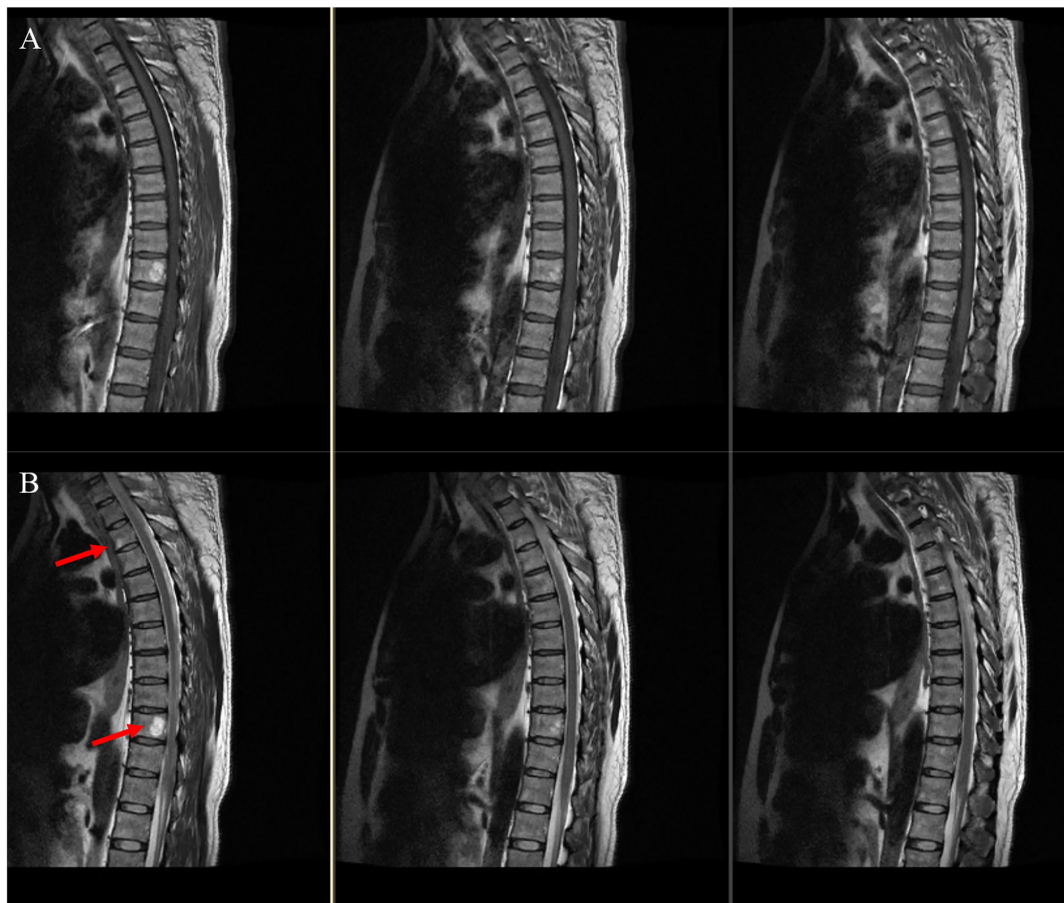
Weighted MRI of the patient's thoracic spine 5 days after the surgery. (A) T1-weighted and (B) T2-weighted MRI images. T3 and T10 vertebral hemangiomas were suspected, as indicated by the red arrow. MRI, magnetic resonance imaging.
